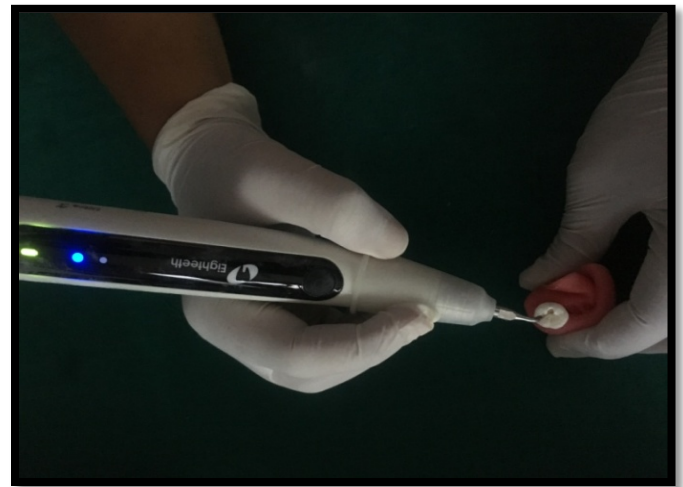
Passive ultrasonic irrigation
